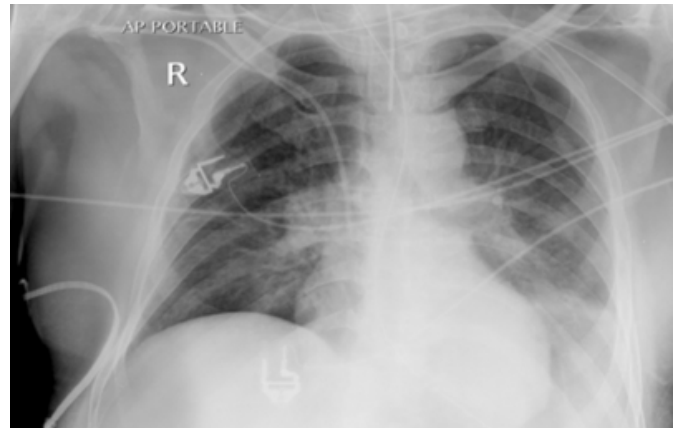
Immediate Post operative X-Ray Chest
